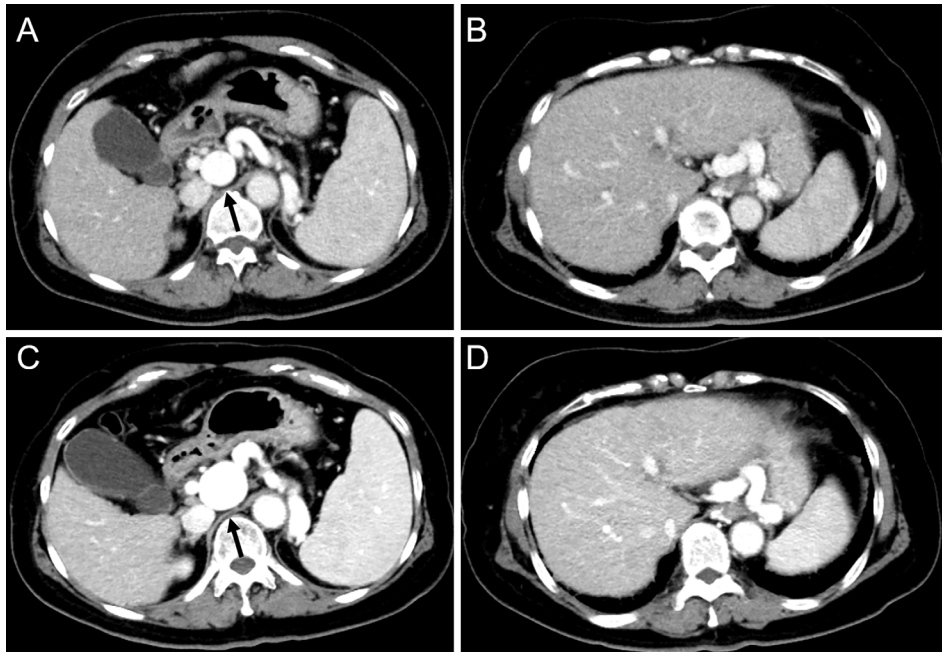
A, B) Dynamic contrast-enhanced computed tomography (CT) showing splenomegaly, a gastrorenal shunt and a saccular left gastric vein aneurysm (A: arrow). C, D) Follow-up CT after 10 months showing enlargement of the aneurysm (C: arrow).
